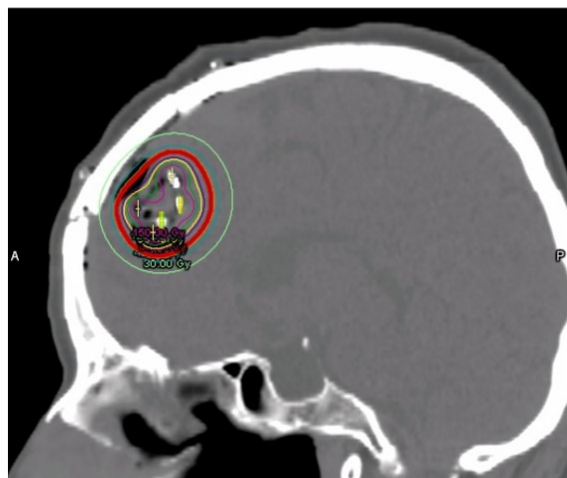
Post-surgery CT scan of collagen tile implants with Cesium-131 seeds.
